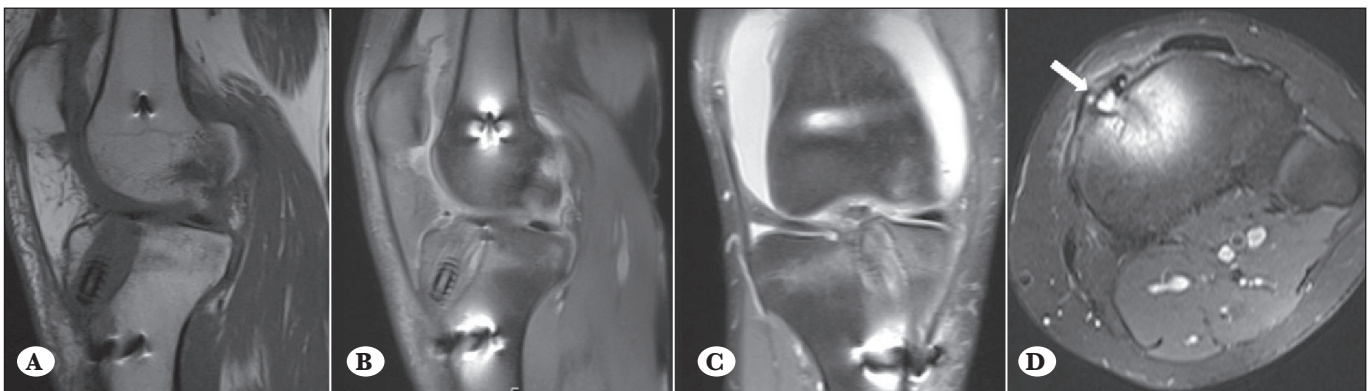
Sagittal T1-weighted (A), sagittal PD-weighted fat suppressed (B), and coronal PD-weighted fat suppressed (C) MR images showing tibial bone tunnel enlargement and fluid that is hypointense on T1-weighted and hyperintense on PD-weighted images. Axial PD-weighted fat suppressed (D) MR image showing extrusion of tunnel fluid (arrow) to the pretibial soft tissue.
